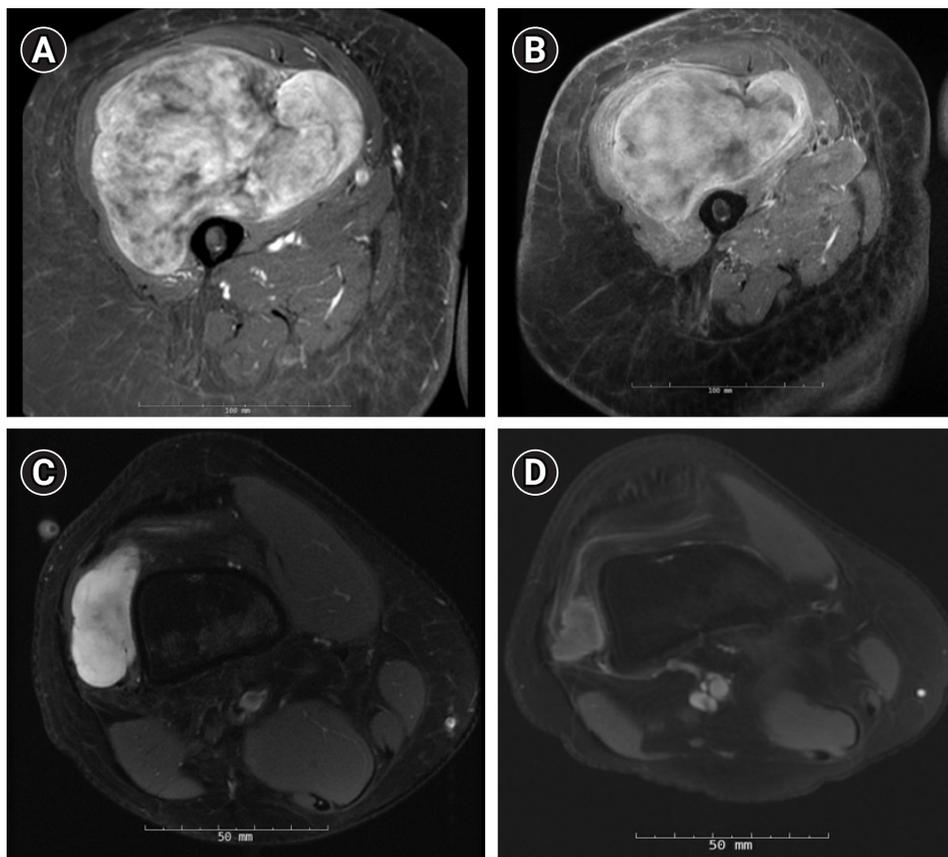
Axial magnetic resonance imaging (MRI) of myxoid liposarcoma with (A) largest dimension of 16 cm on presentation and (B) largest dimension of 14 cm after radiotherapy (RT). Axial MRI of myxoid liposarcoma with (C) largest dimension of 5.5 cm on presentation and (D) largest dimension of 2.1 cm after RT.
